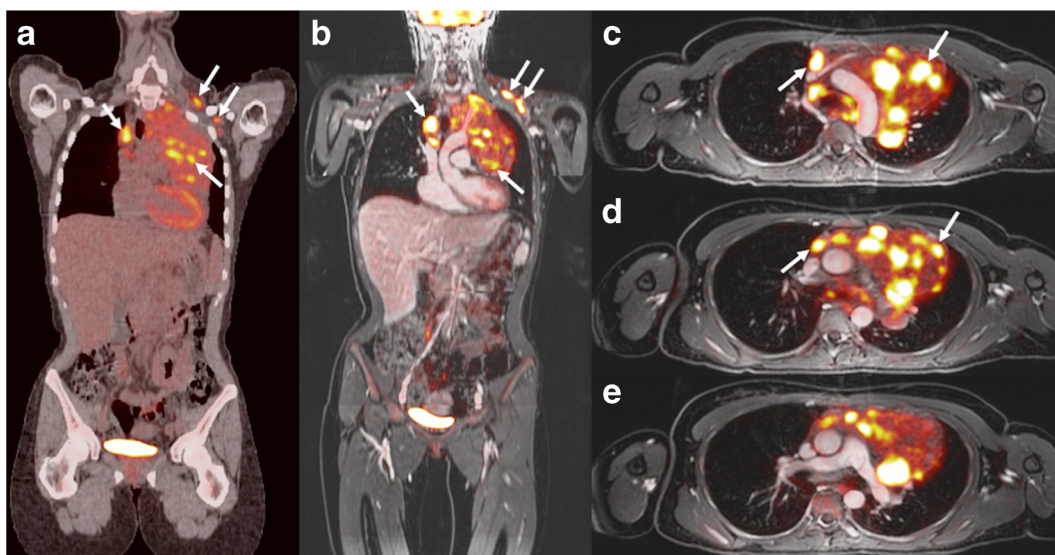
$[^{18}\text{F}]\text{FDG}$ PET/CT and PET/MR in a 23-year-old girl with Hodgkin's lymphoma. a Coronal PET/CT shows mediastinal and left infraclavicular $[^{18}\text{F}]\text{FDG}$ -avid lymph nodes (*white arrows*). b–e Corresponding coronal and axial T1-weighted LAVA scan (TR/TE/Flip angle: 4.2/1.7/15) after intravenous ferumoxytol injection with superimposed $[^{18}\text{F}]\text{FDG}$ PET scan demonstrates mediastinal and infraclavicular $[^{18}\text{F}]\text{FDG}$ -avid lymph nodes (*white arrows*). The findings on PET/CT and PET/MR are concordant.
